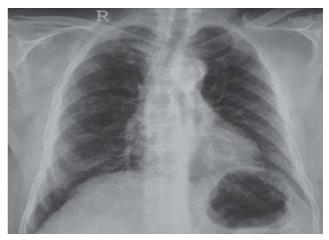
Chest radiograph (postero-anterior view) showing few bilateral lower zone reticulo-nodular opacities.
